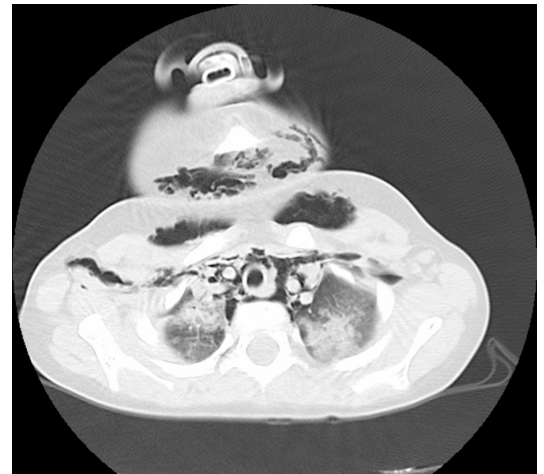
Thoracic CT scan revealing extensive cervical subcutaneous emphysema, left hydropneumothorax, and right pneumothorax and pneumomediastinum.
